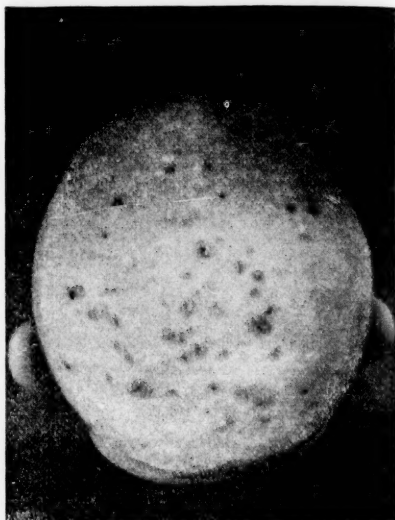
Multiple patches of ringworm of scalp with loss of hair following exposure to x-ray as a curative measure. Properly administered, this x-ray loss of hair is temporary.
